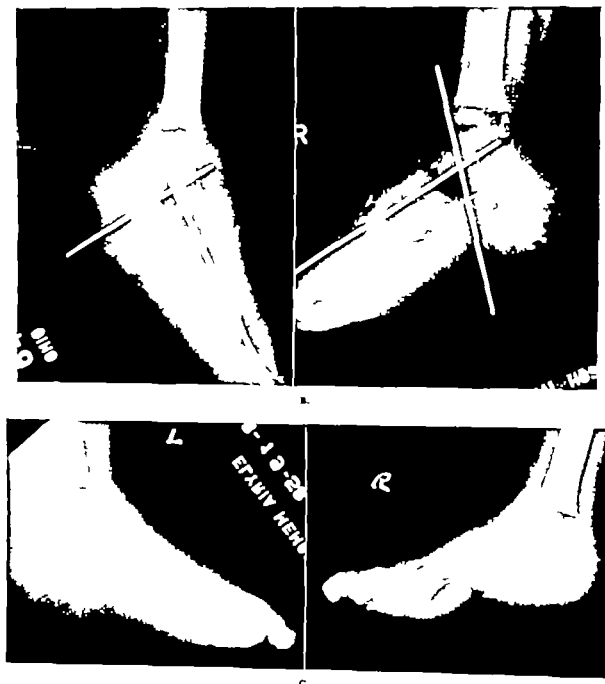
(cont'd) B, Lateral roentgenograms made June 18, 1938, when postoperative casts were changed. The fore parts of the feet now appear to be in good alignment with the hind parts, and the luxation of the talonavicular joint appears to be reduced. C, Good reduction of the deformity of the left foot, Aug. 19, 1938, but reduction of the deformity was not maintained in the right foot. The Achilles tendon had been lengthened in the left foot, but not at the right.
